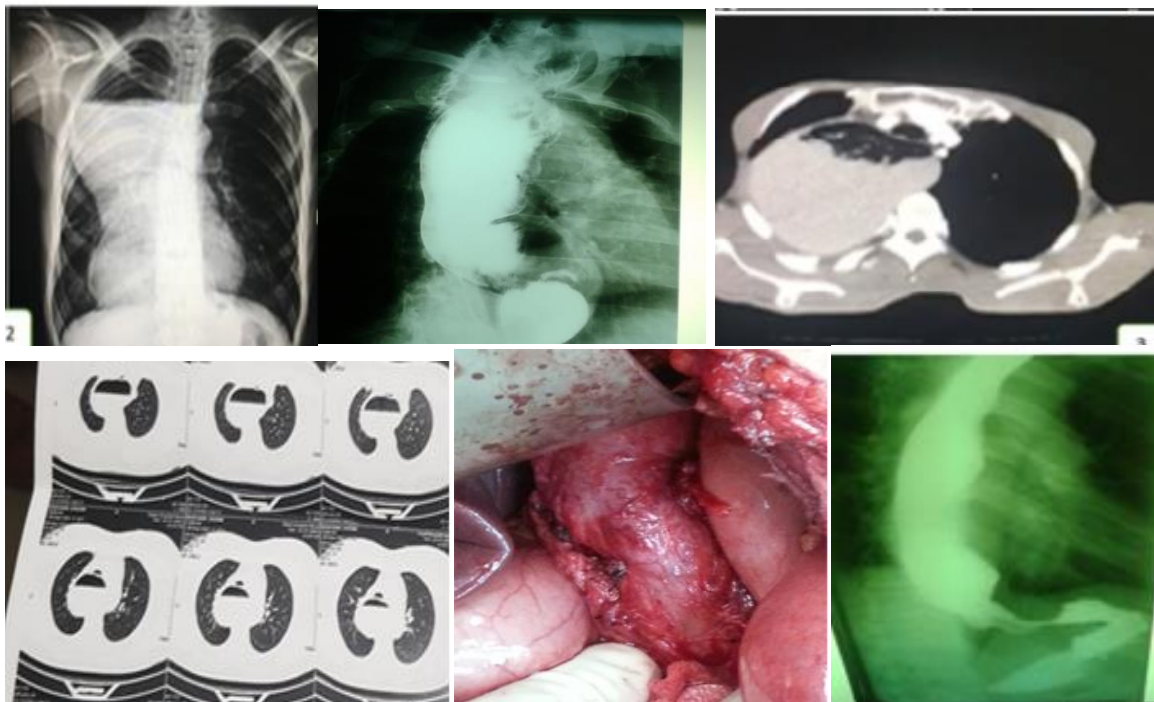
CXR, show barium swallow, CT-scan of chest with sever dilation, cardiomyotom and show post operative barium swallow
